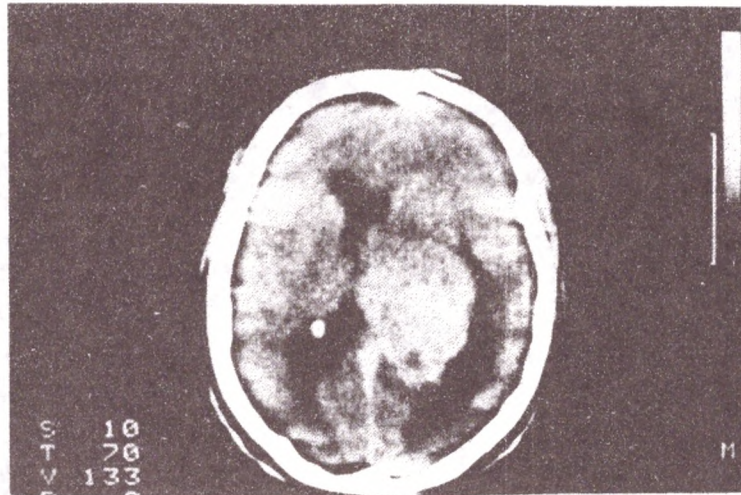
CT-scan shows tumor (subependymoma) involving the septum pellucidum and the frontal horn of the left lateral ventricle*
